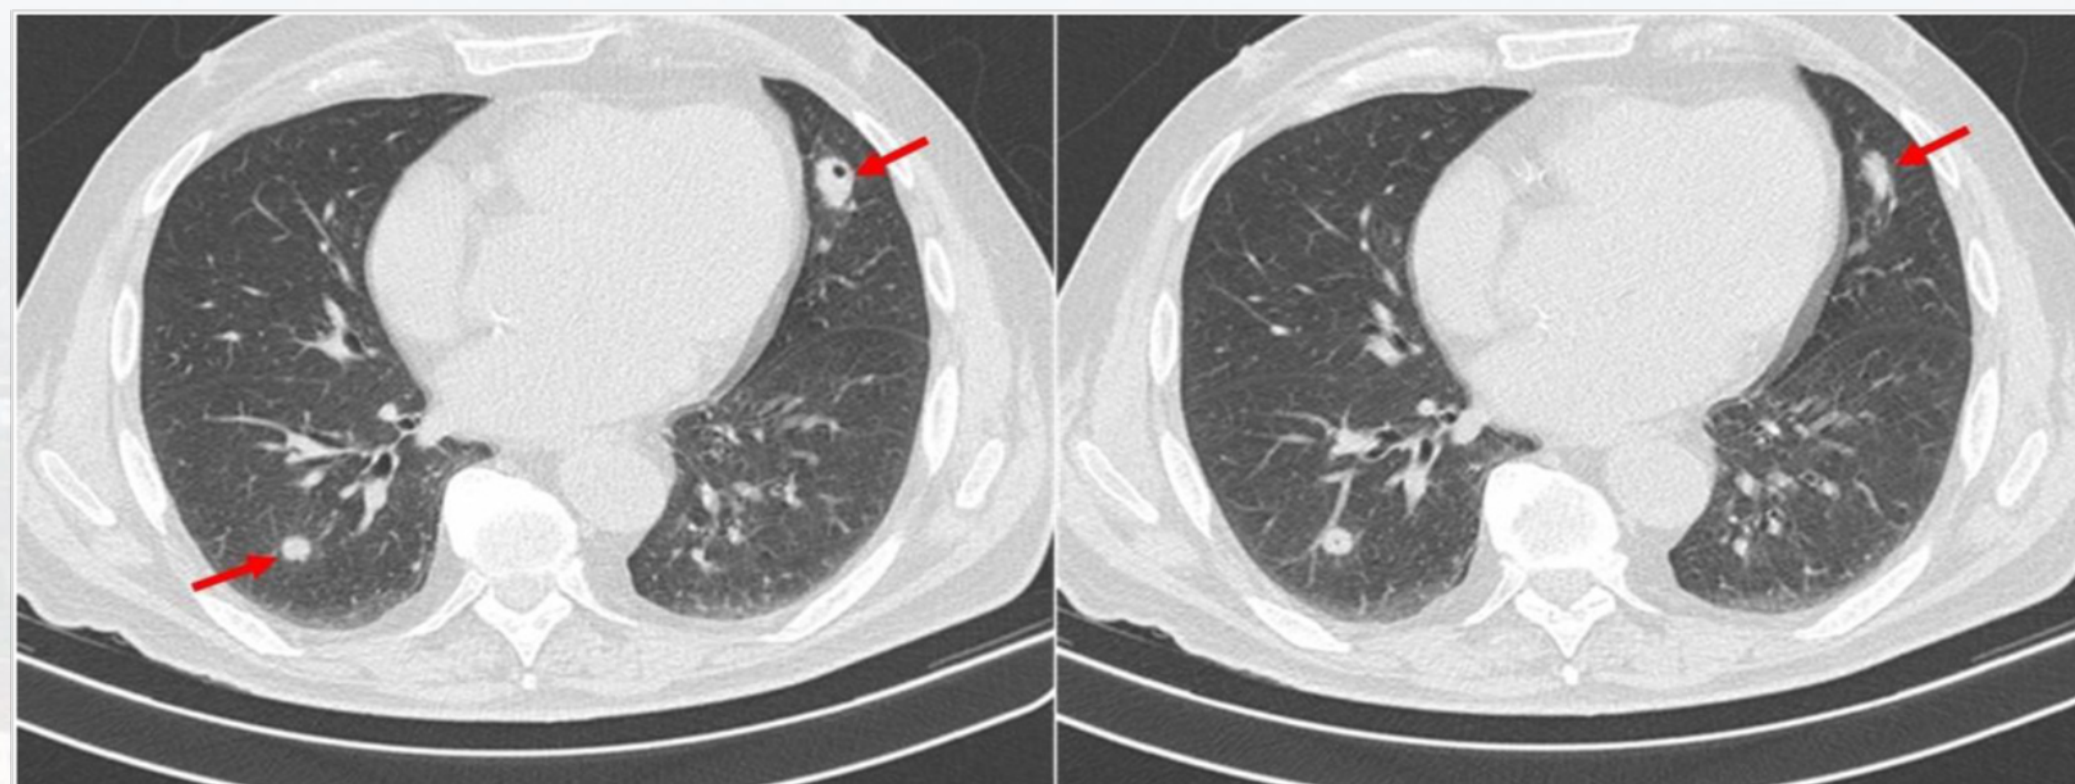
Chest HRCT showing multiple pulmonary nodules (arrows) some of them with small cavitation areas, before corticosteroid treatment.
